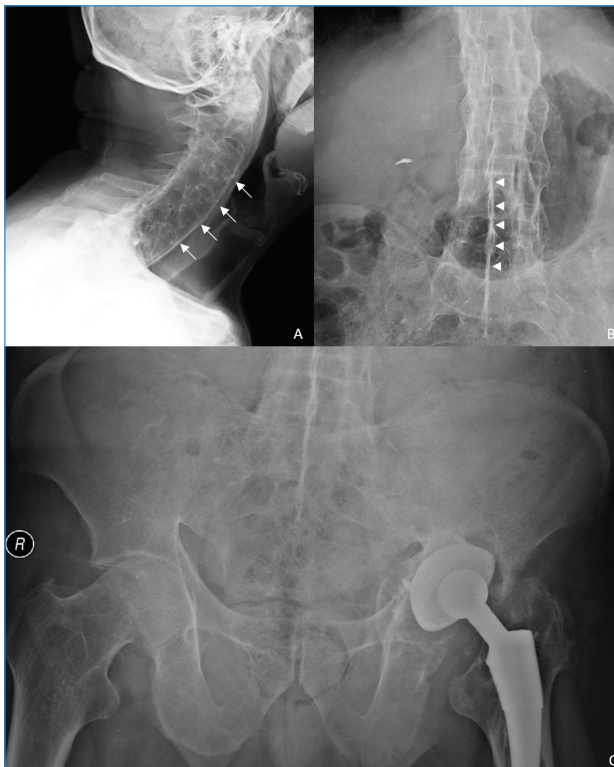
Classical spondyloarthritis radiographical findings.
